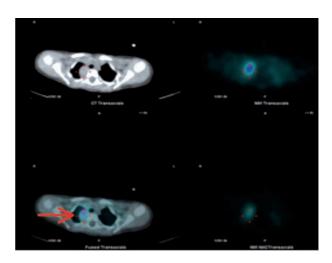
MIBG- SPET scintigraphy: increased uptake of radio-labelled tracer in the right portion of the anterior-superior mediastianum
